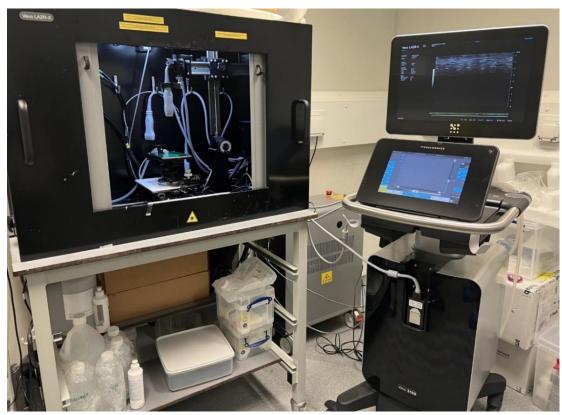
Ultrasound imaging system. VisualSonics Vevo 3100 system with a VisualSonic MX550S linear array transducer and hardware to control the system.
